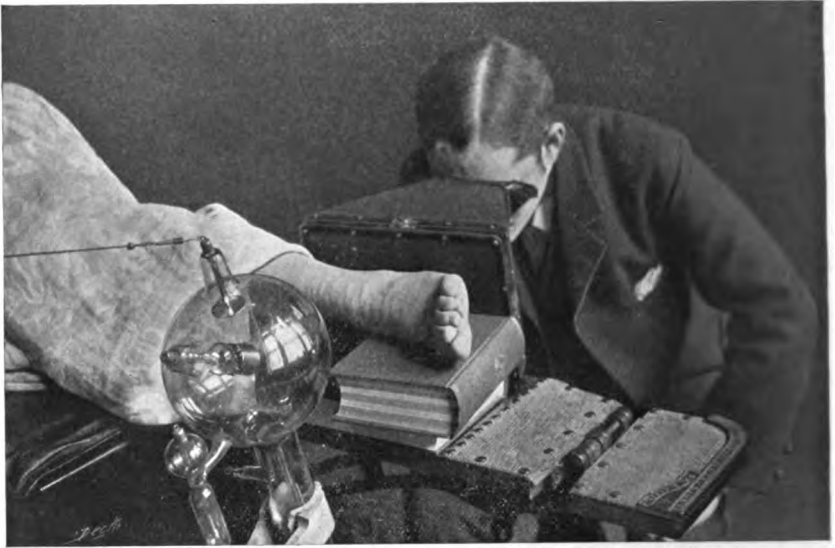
Fluoroscopy of the ankle preliminary to radiography with the lateral plateholder. An extremely dangerous practice.
